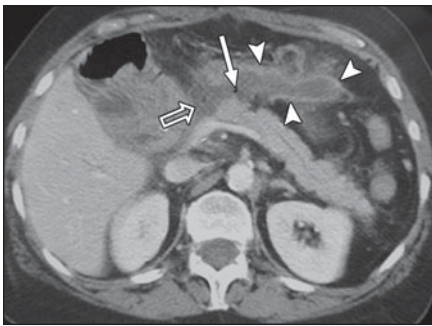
62-year-old woman 7 days after pancreaticoduodenectomy for duodenal stromal tumor. Transverse contrast-enhanced helical CT scan of abdomen shows perianastomotic fluid collection measuring maximum of 10×1 cm close to anastomosis (open arrow), containing air bubbles (arrow), and exhibiting wall enhancement (arrowheads). Pancreatic remnant has normal enhancement without signs of postoperative pancreatitis or dilatation of pancreatic duct. Clinicobiologic diagnosis was pancreatic fistula on postoperative day 7. Both radiologists made correct diagnosis.
